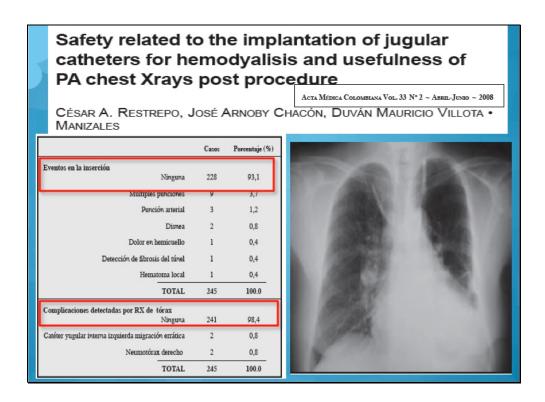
PA chest radiograph post insertion of central catheter is unnecessary.
